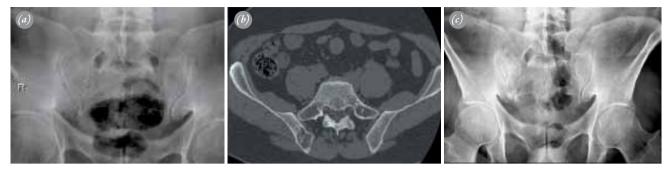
Forty-four years old male admitted with pain in the right sacroiliac region. (a) Anteroposterior radiograph demonstrates a cystic bone lesion in the right iliac bone adjacent to the sacroiliac joint. (b) Computed tomography image of the lesion. (c) After intralesional curettage and grafting, there was no radiological sign of recurrence on the anteroposterior radiograph of the pelvis taken at the 29th month follow-up.
